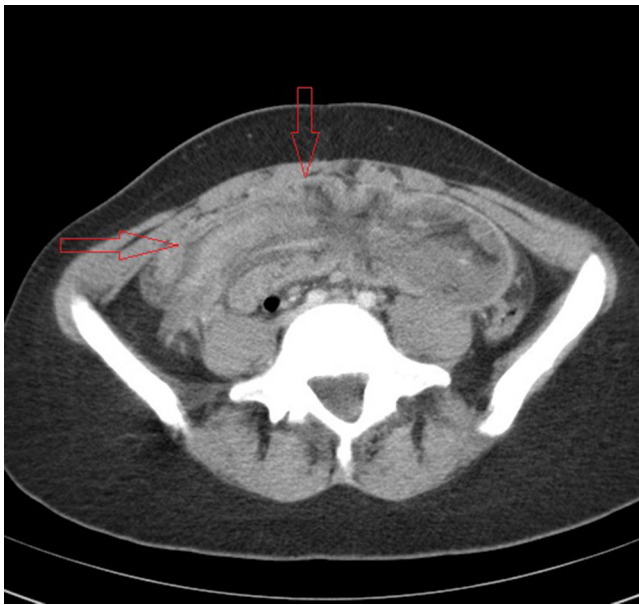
CT scan revealing a cecocolic intussusception (arrows).
